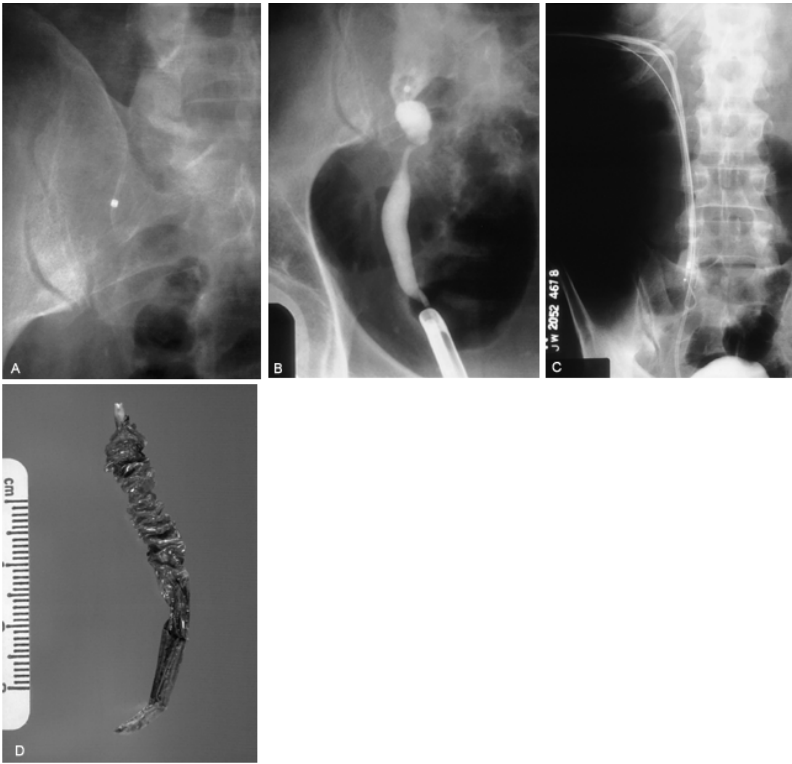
A: Plain radiograph reveals a metallic foreign body over the iliac bone. This represents the tip of a balloon catheter that became dislodged during an attempted balloon dilation for a ureteral stricture. B: Retrograde study confirms ureteral stricture below the level of the foreign body, which precludes its removal via retrograde ureteroscopic access. C: Antegrade approach using flexible instrumentation. D: The foreign body was extracted intact via an antegrade approach. The ureteral stricture was subsequently managed in an antegrade endourologic fashion.
